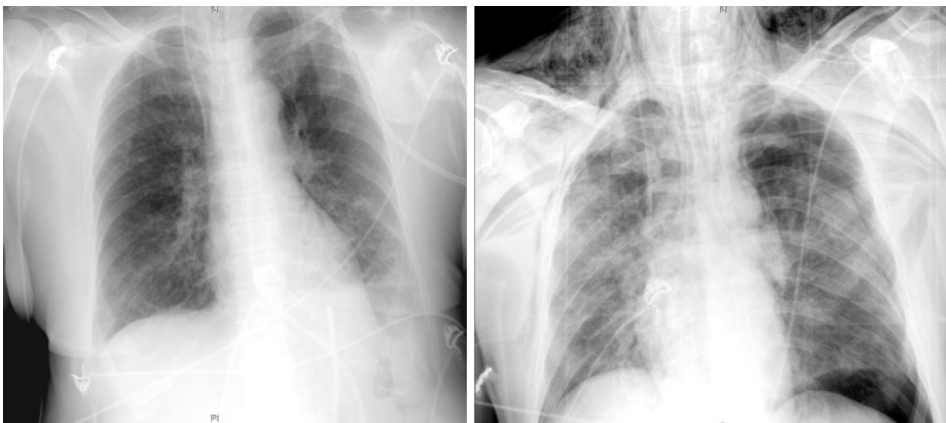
AP chest X-ray findings. AP chest X-ray findings (left) in an 80-year-old man with bilateral COVID-19 pneumonia and associated left pleural effusion. AP chest X-ray findings (right) in an 84-year-old man with bilateral alveolar infiltrates, diffusely distributed and left tension pneumothorax with subcutaneous emphysema.
